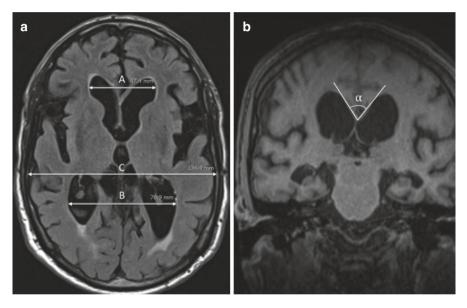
MRI images of an 83-year-old male with iNPH. Image (a) is an axial T2-FLAIR image demonstrating enlarged ventricles with an Evan's ratio (A/C) of 0.35 and a frontal and occipital horn ratio (A + B)/2C of 0.46. Image (b) is a coronal T1-weighted image demonstrating a callosal angle, α of 70% at the level of the posterior commissure
